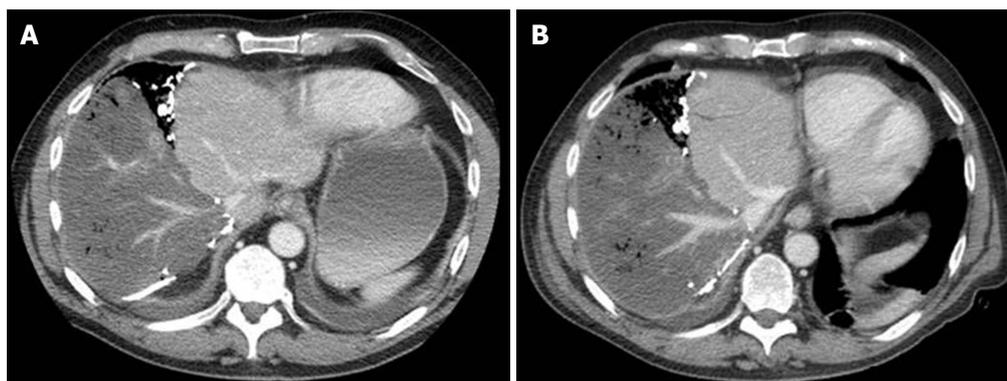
Post-operative late venous phase computed tomography with contrast enhancement of the hepatic venous system of the ischemic right hemi-liver on (A) day 3 and (B) day 6.
